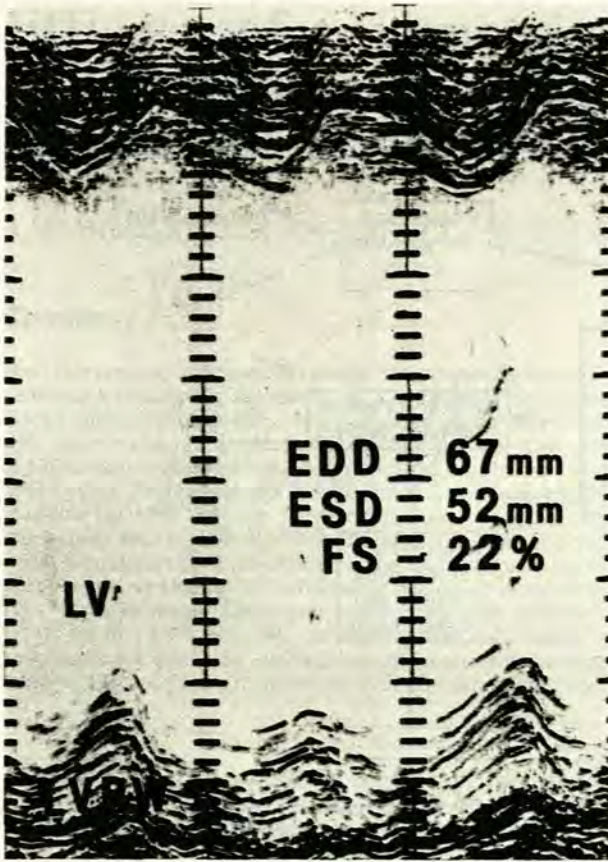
M-mode echocardiogram demonstrating a dilated left ventricular (LV) cavity with poor contraction in a patient with severe rheumatic mitral regurgitation (EDD = end-diastolic diameter; ESD = end-systolic diameter; FS = fractional shortening).
